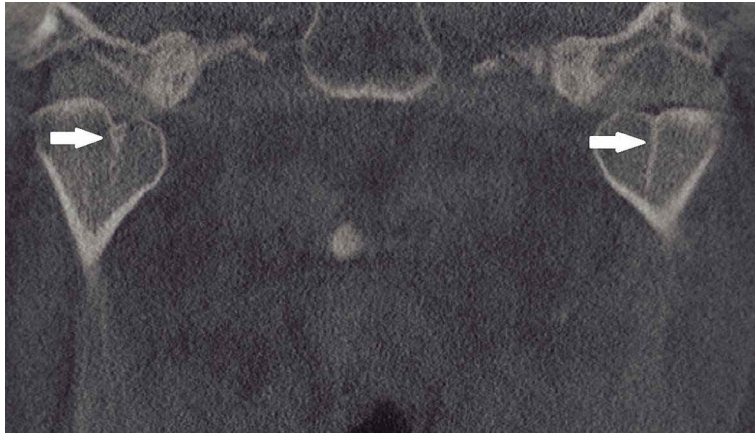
A coronal CBCT slice shows the bilateral bifid mandibular condyle (arrows).
